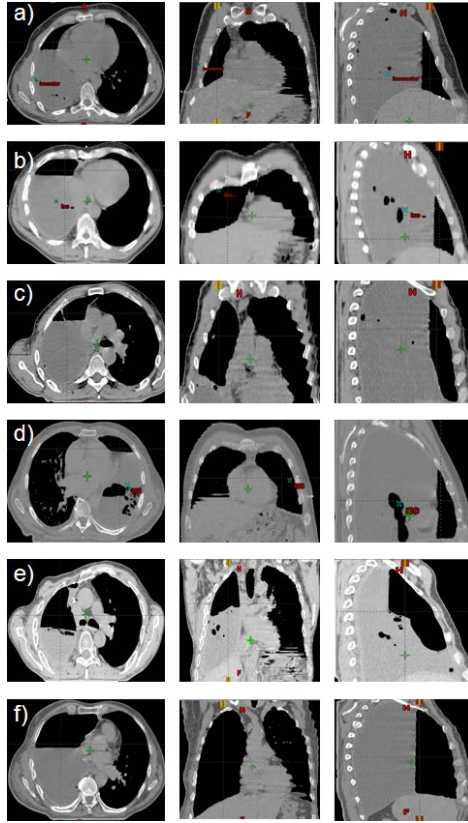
Air cavities remaining in the resected lung at the date of the planning CT in the axial (left images), coronal (middle images) and sagittal (right images) view. Five patients had a right sided MPM (a, b, c, e and f) and one patient had a left sided MPM (d). The volume of the air cavities are  $150 \text{ cm}^3$  (a),  $225 \text{ cm}^3$  (b),  $243 \text{ cm}^3$  (c),  $276 \text{ cm}^3$  (d),  $379 \text{ cm}^3$  (e) and  $1276 \text{ cm}^3$  (f).
